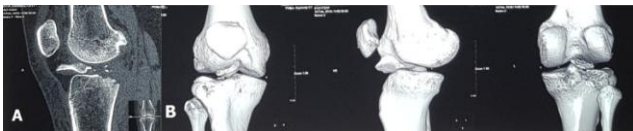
Sagittal CT image of the knee showed the fragment was originated from the posterior side of the tibial plateau A); Three-dimension CT showed the exact site of PCL avulsion fracture B)
